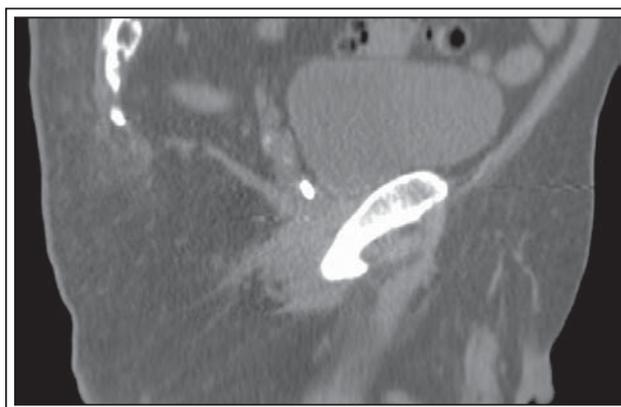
Sagittal CT image of electromagnetic transponder beacon in prostatic bed.
